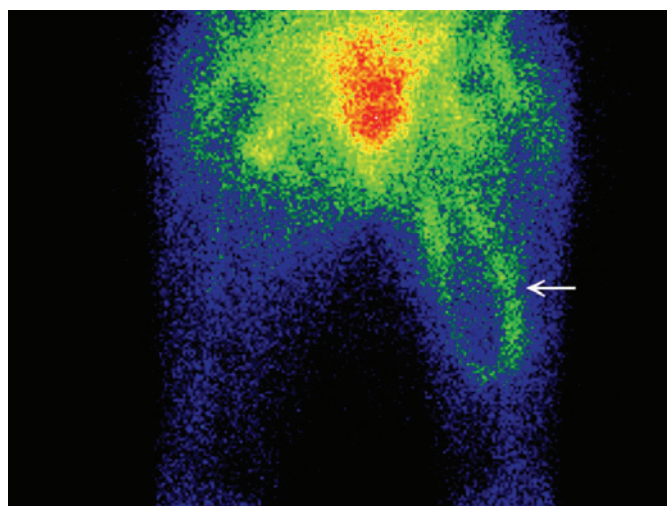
Radionuclide imaging of infection. Gallium scintigraphy demonstrated prominent visualization of the hemodialysis access graft (arrow) in the left thigh.
